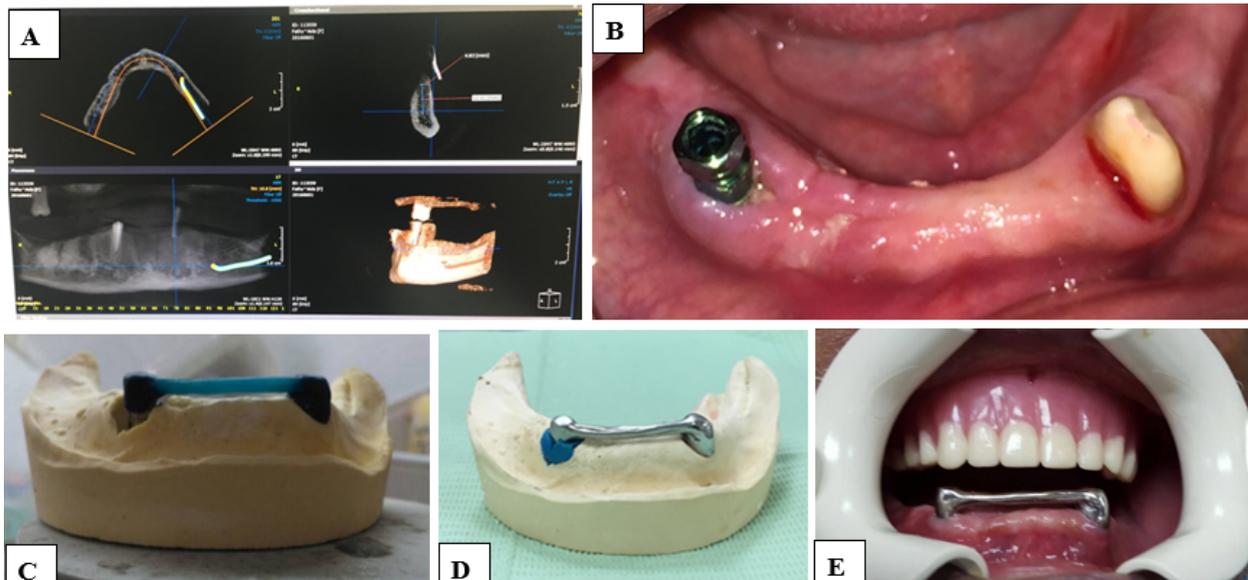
A: CBCT to evaluate the bone dimensions in the implant site, B: Impression transfer coping screwed into the fixture for impression making, C: Bar plastic pattern attached to the copings' wax pattern, D: The cast metal bar, E: The cast metal bar tried in its position intra-orally.
